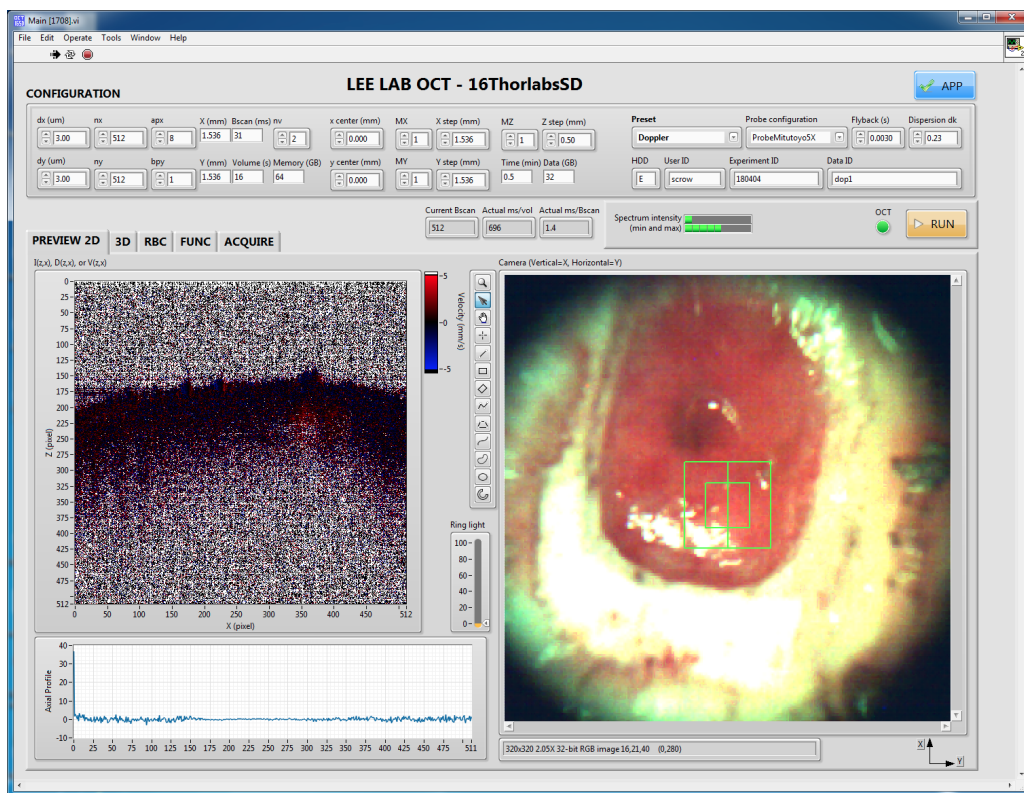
Figure B 2: Screenshot of custom Lee Lab OCT Software. Settings for Doppler OCT.
